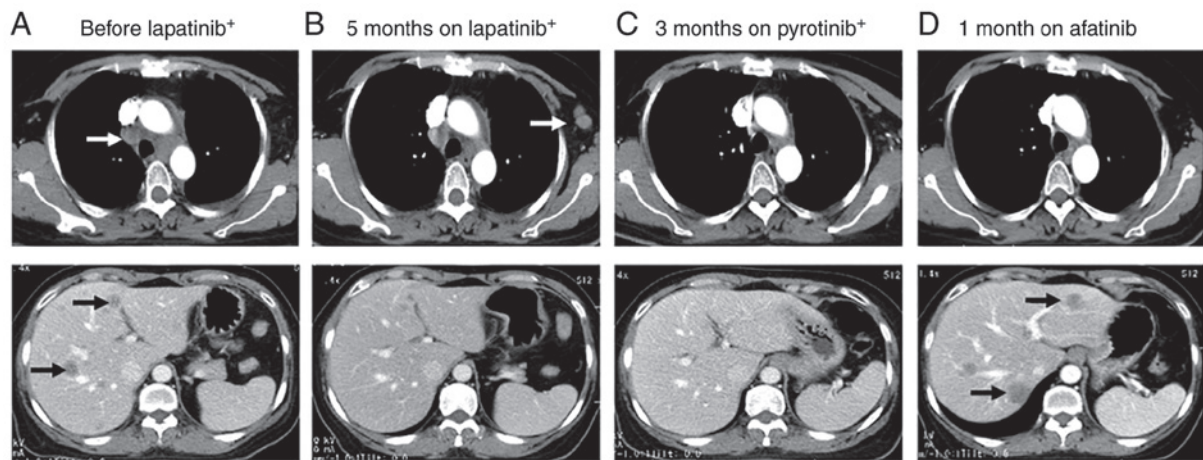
A 53-year-old female Chinese non-smoker was diagnosed with stage IV adenocarcinoma of the left lung with HER2 amplification on next-generation sequencing. CT images of the chest (upper panels) and upper abdomen (lower panels) are shown. (A) CT scan after two cycles of pemetrexed plus platinum revealed mediastinal lymph node metastasis and liver metastasis. After one cycle of albumin-conjugated paclitaxel, platinum and bevacizumab, the patient was treated with lapatinib plus chemotherapy. (B) The patient achieved partial response after treatment with lapatinib plus chemotherapy; however, 5 months later, the disease progressed with left axillary lymph node metastasis. (C) The patient achieved complete response 3 months after pyrotinib plus chemotherapy. (D) The disease started to slowly progress 6 months after pyrotinib therapy. The regimen was switched to afatinib; however, one month later, the disease progressed with the appearance of new hepatic lesions. Arrows, target lesions; +, plus chemotherapy.
